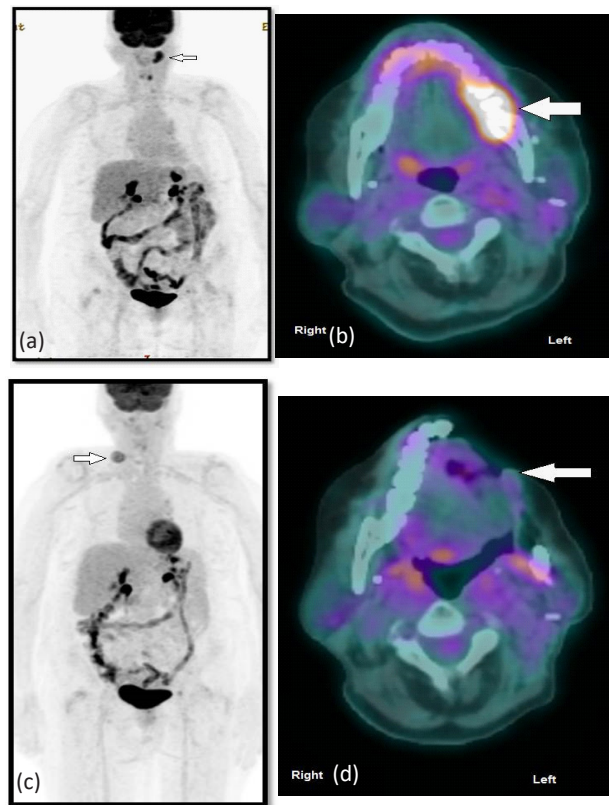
18F FDG PET CT and maximum intensity projection (MIP): Preoperative study showed FDG avid left mandible lesion with no suspicious local lymph nodes or distant metastases (a, b). Post-operative study showed no residual disease activity in left mandible and suspicious FDG avid lymph node metastases (arrow) in right lower neck (c,d).
